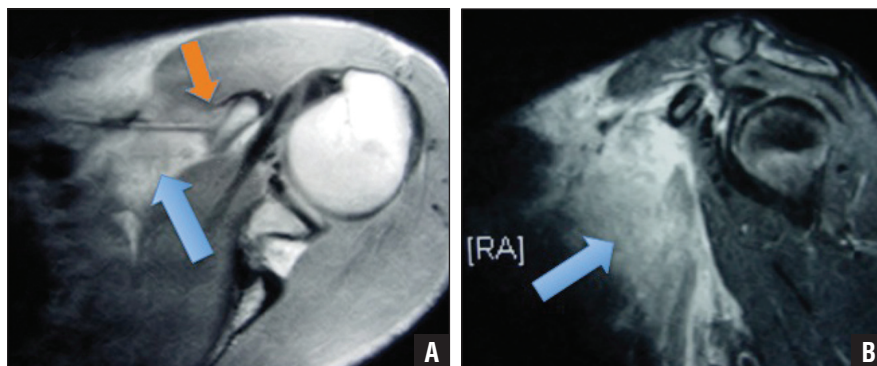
Axial T1-weighted magnetic resonance image showing high signal at the pectoralis minor muscle tendon junction (arrow) with muscle retraction and rupture at the musculotendinous junction (orange arrow) (A). Sagittal T2-weighted magnetic resonance image showing significant edema (arrow) within the pectoralis minor muscle and detachment of the tendon from the coracoid (B).
